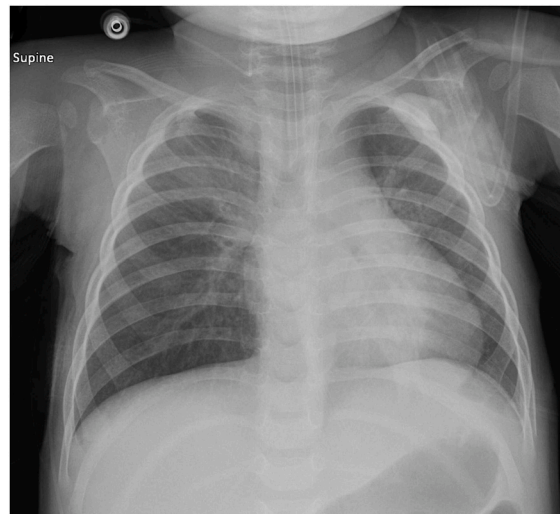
Day 9 chest X-ray before extubation.
